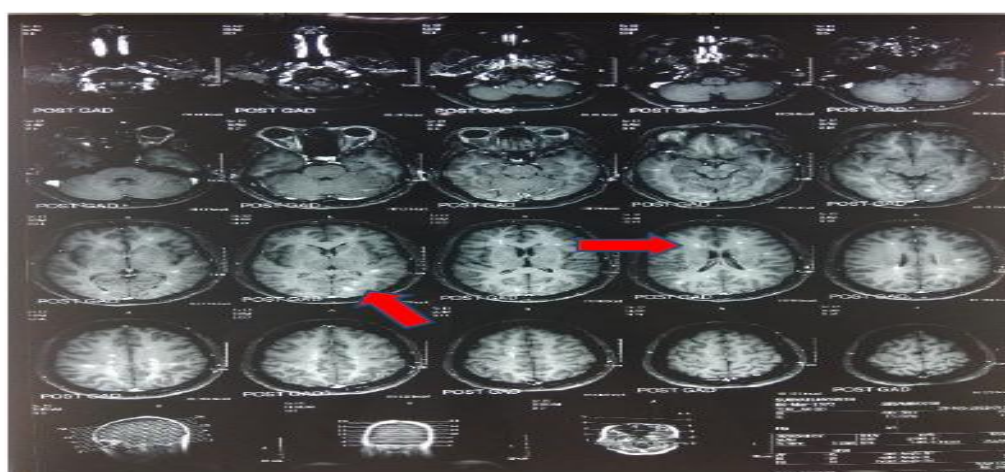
T1 Weighted Brain MRI before administration of intravenous immunoglobulin showing multiple enhancing lesions in the juxtacortical parietal both sides (left >), on the left and right lateral periventricle with Dawson's finger (+) in accordance with Multiple Sclerosis, bilateral optic neuritis.
